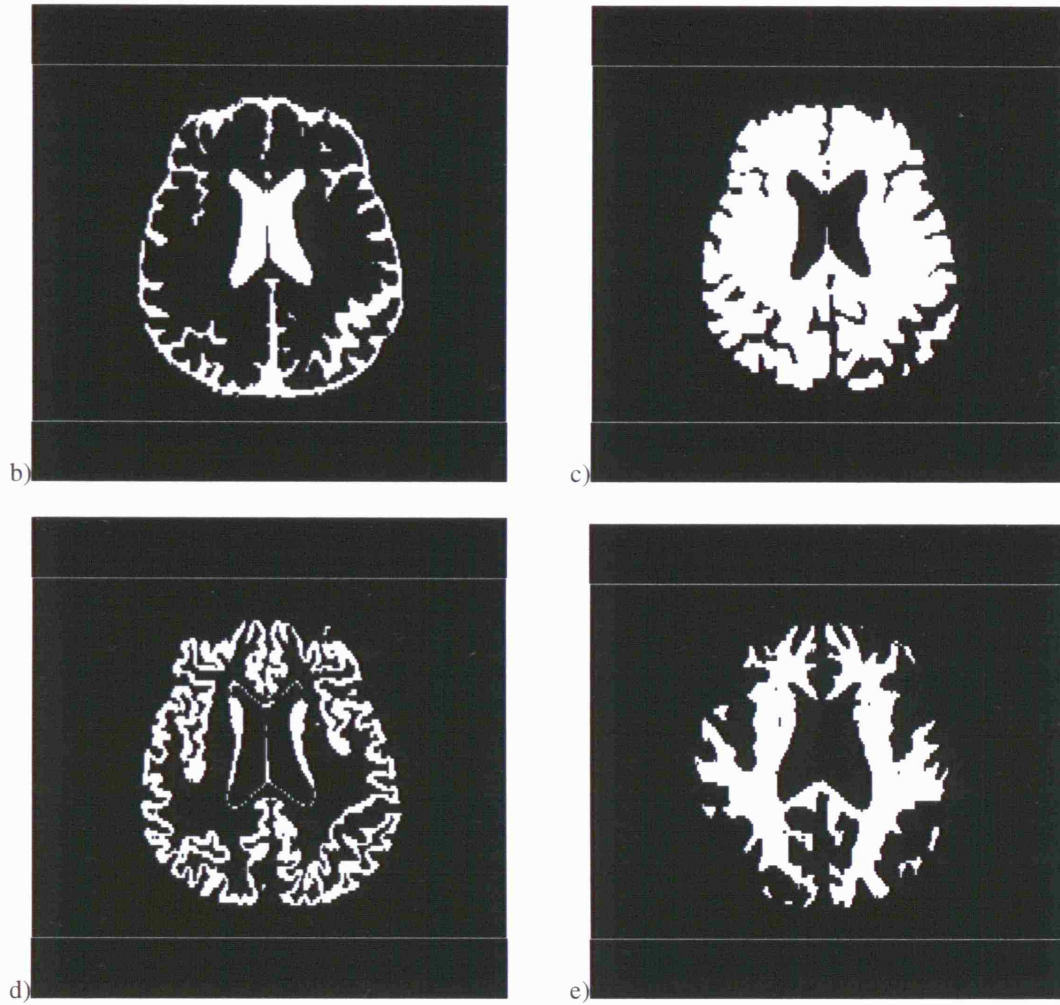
FAST segmentation a) used to segment axial T1-weighted images into CSF b), whole brain c), grey matter d) and white matter e)
